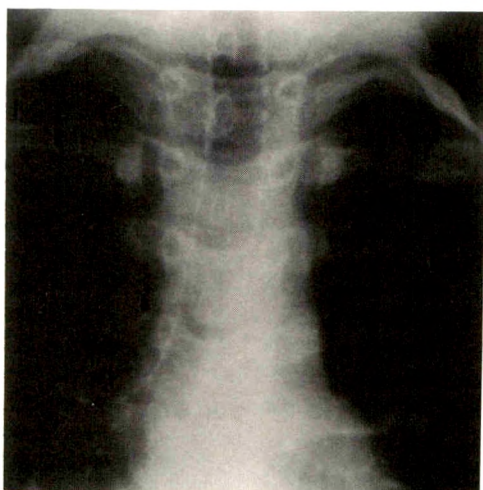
Tracheal and bronchial calcification associated with warfarin therapy in an 11-year-old girl who had mitral valve replacement when she was 5 years old. Chest radiograph shows calcification in wall of trachea and main bronchi. Calcifications were first noted when the patient was 8 years old, 3 years after start of warfarin therapy, and had progressively increased. There were no respiratory symptoms. (Reprinted with permission from Taybi and Capitanio [47].)
